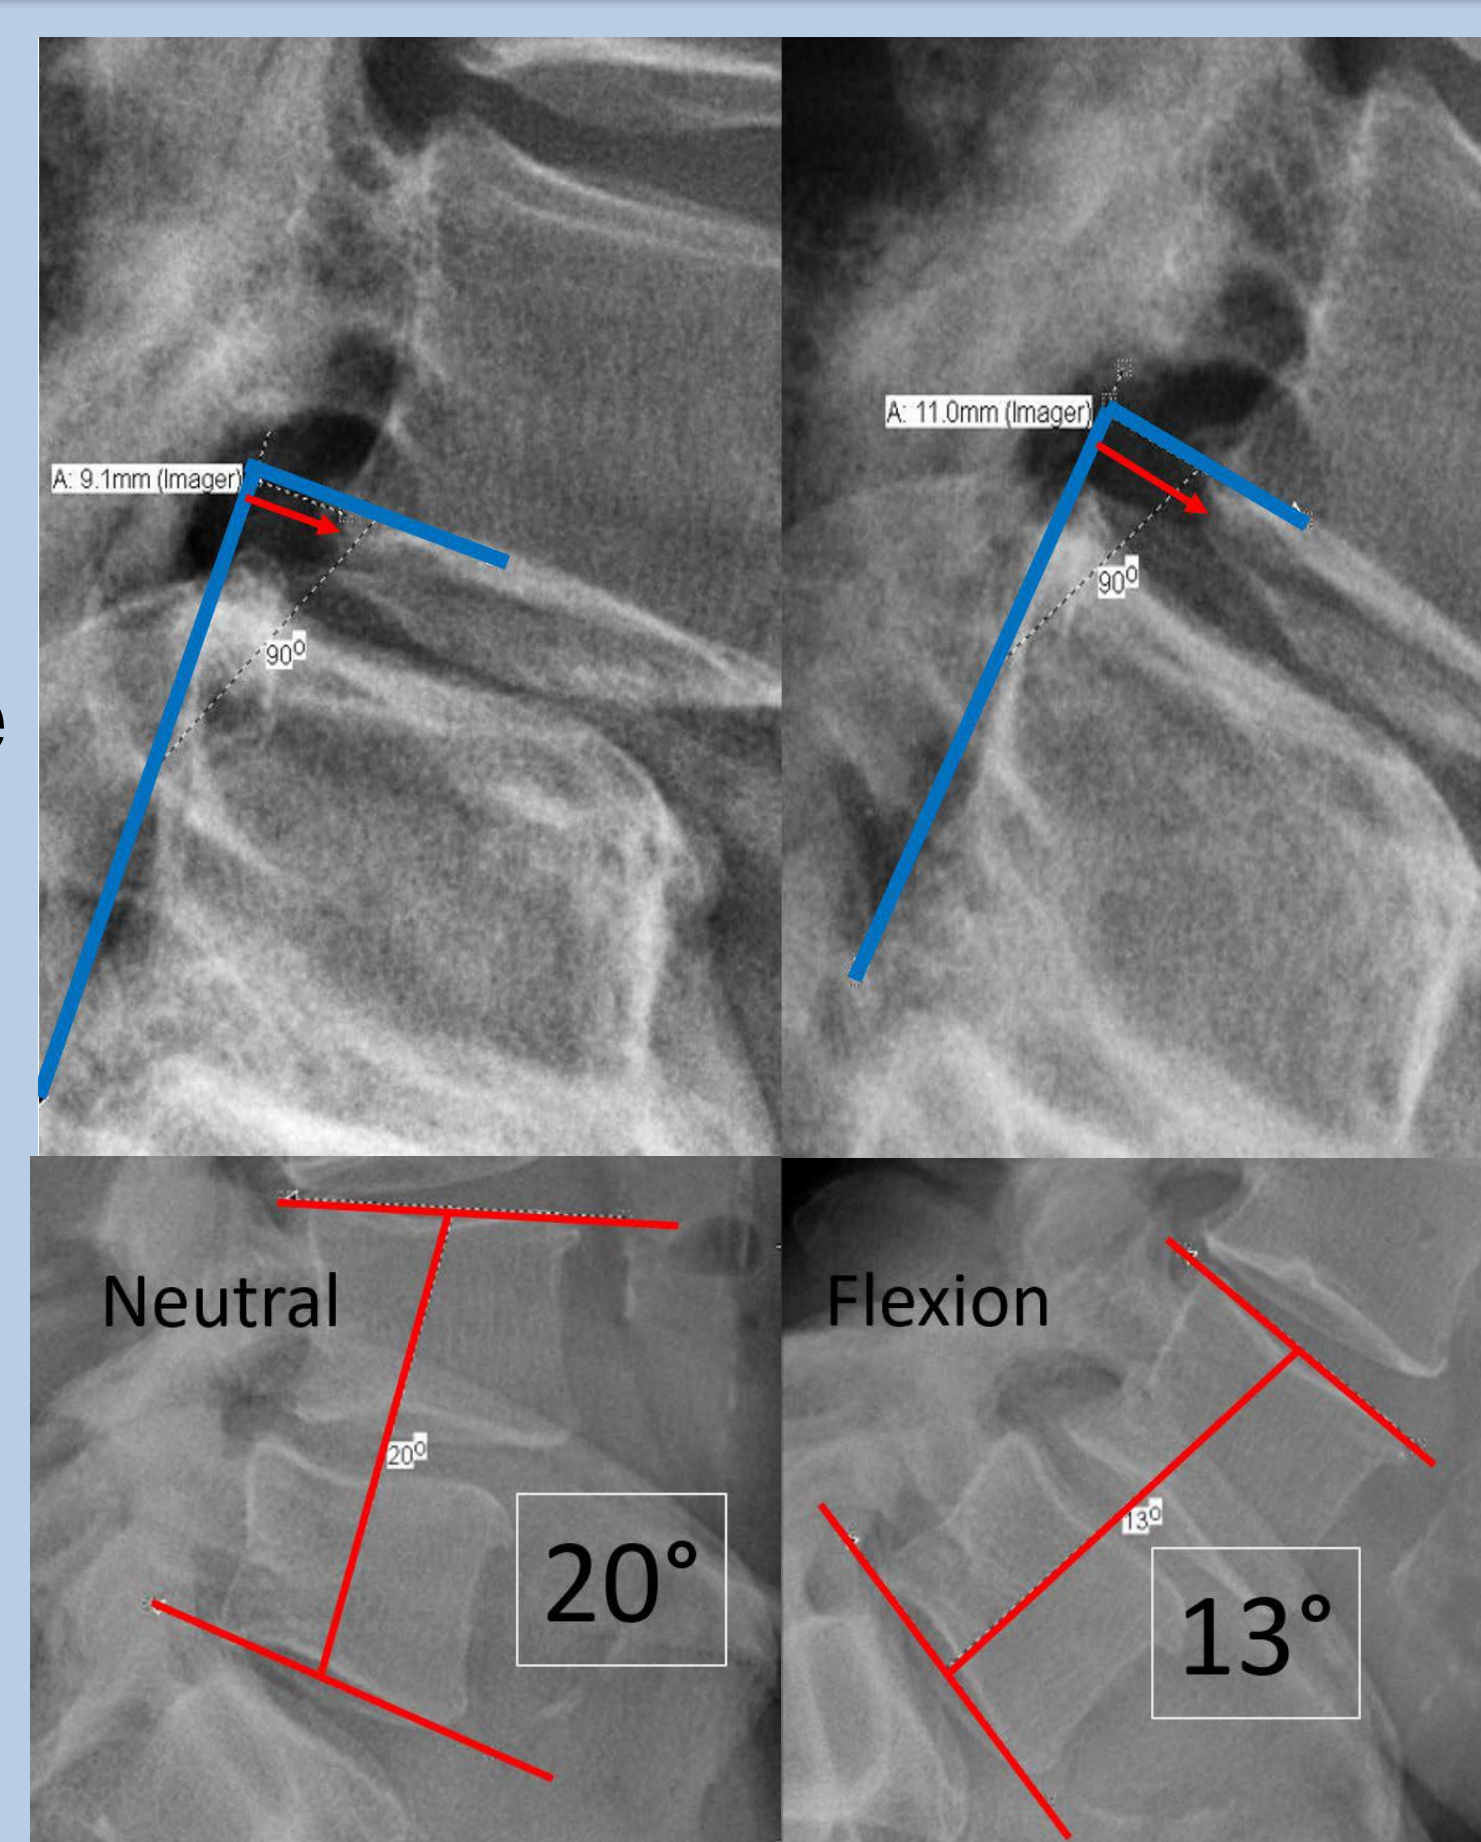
Clinical functional radiographs demonstrating AP slip (top) and intervertebral flexion (bottom). A change in AP translation greater than 3mm indicated dynamic instability⁶⁻¹⁰.
